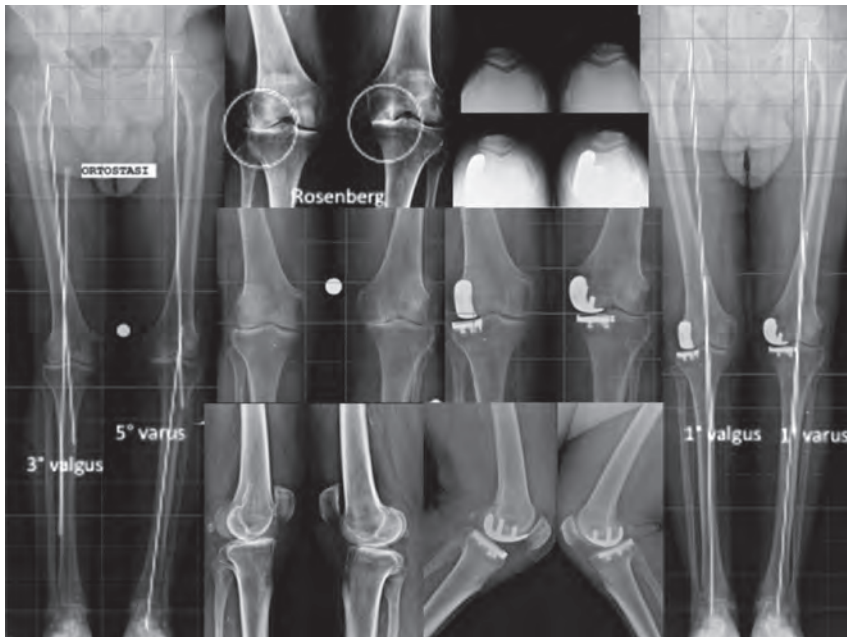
83 years old man with right knee lateral OA and left knee medial OA. He had simultaneous bilateral UKR. Postoperative X-rays showed undercorrection of the coronal deformity to respect the native morphotype.
